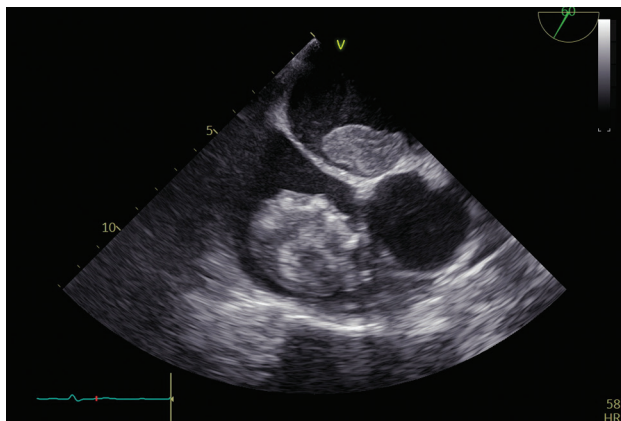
60-degree view transesophageal echocardiography image showing right (54x36 mm) and left (35x15 mm) atrial masses.
